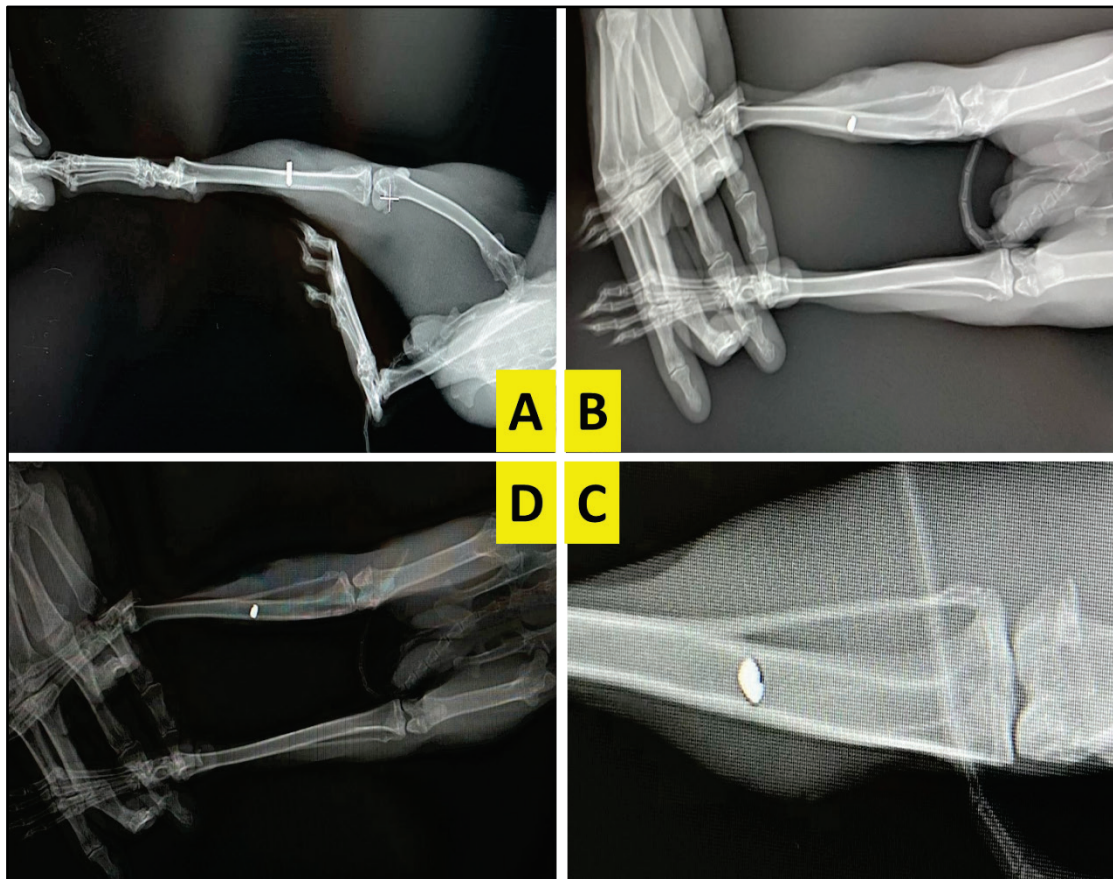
Representative X-ray of the tibia bone with inserted implant localized inside the bone to confirm the proper surgical induction methods and well-maintained implant without failure: (A) side image, (B) anterior image, (C) close image, (D) top image
